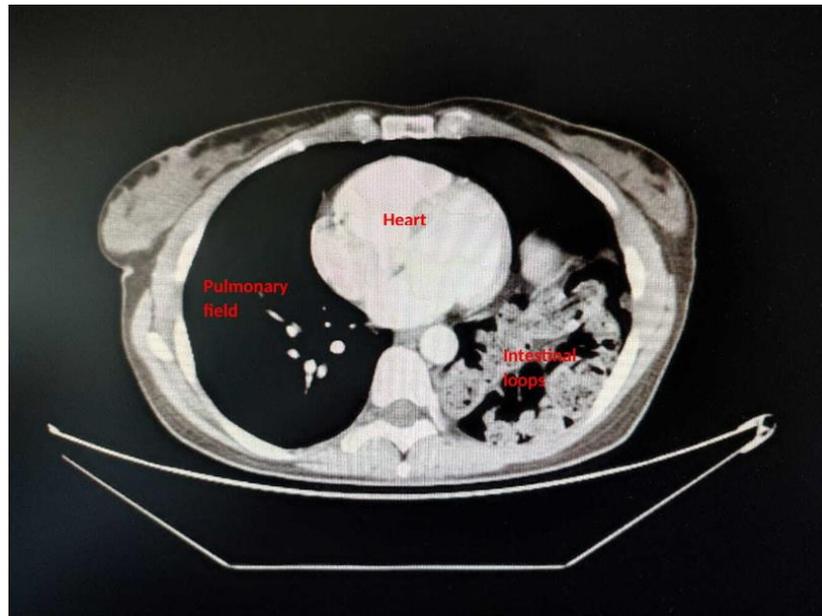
CT scan showed an asymmetry of the pulmonary fields due to a suspected left posterolateral hernia (Bochdalek's hernia) with evidence of intestinal loops.
